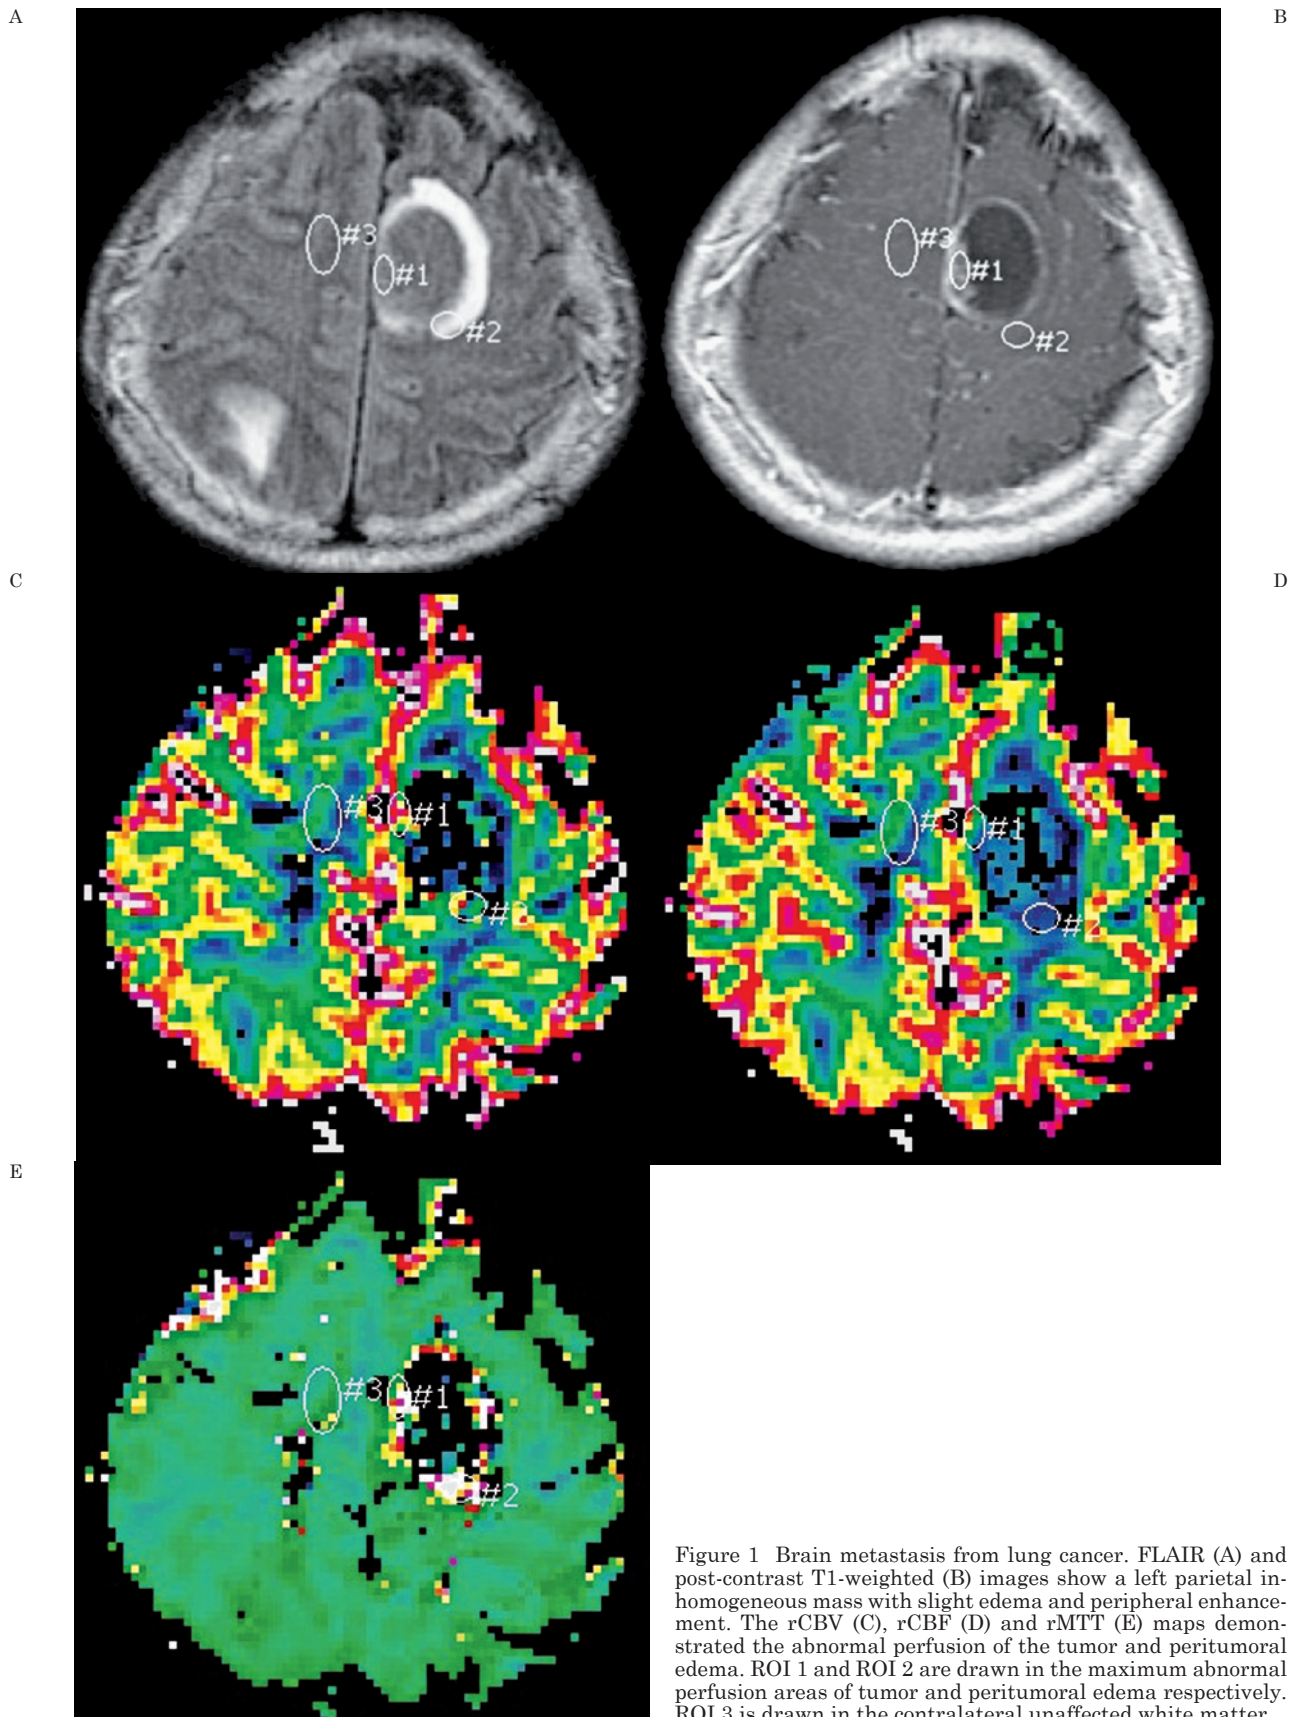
Brain metastasis from lung cancer. FLAIR (A) and post-contrast T1-weighted (B) images show a left parietal inhomogeneous mass with slight edema and peripheral enhancement. The rCBV (C), rCBF (D) and rMTT (E) maps demonstrated the abnormal perfusion of the tumor and peritumoral edema. ROI 1 and ROI 2 are drawn in the maximum abnormal perfusion areas of tumor and peritumoral edema respectively. ROI 3 is drawn in the contralateral unaffected white matter.
